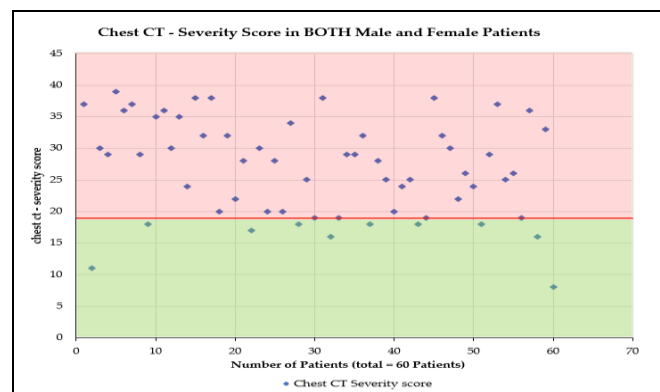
Chest CT - Severity Score in Patients Aged 50 and above with Diabetes Mellitus and Hypertension as Co-Morbids (n=60)
